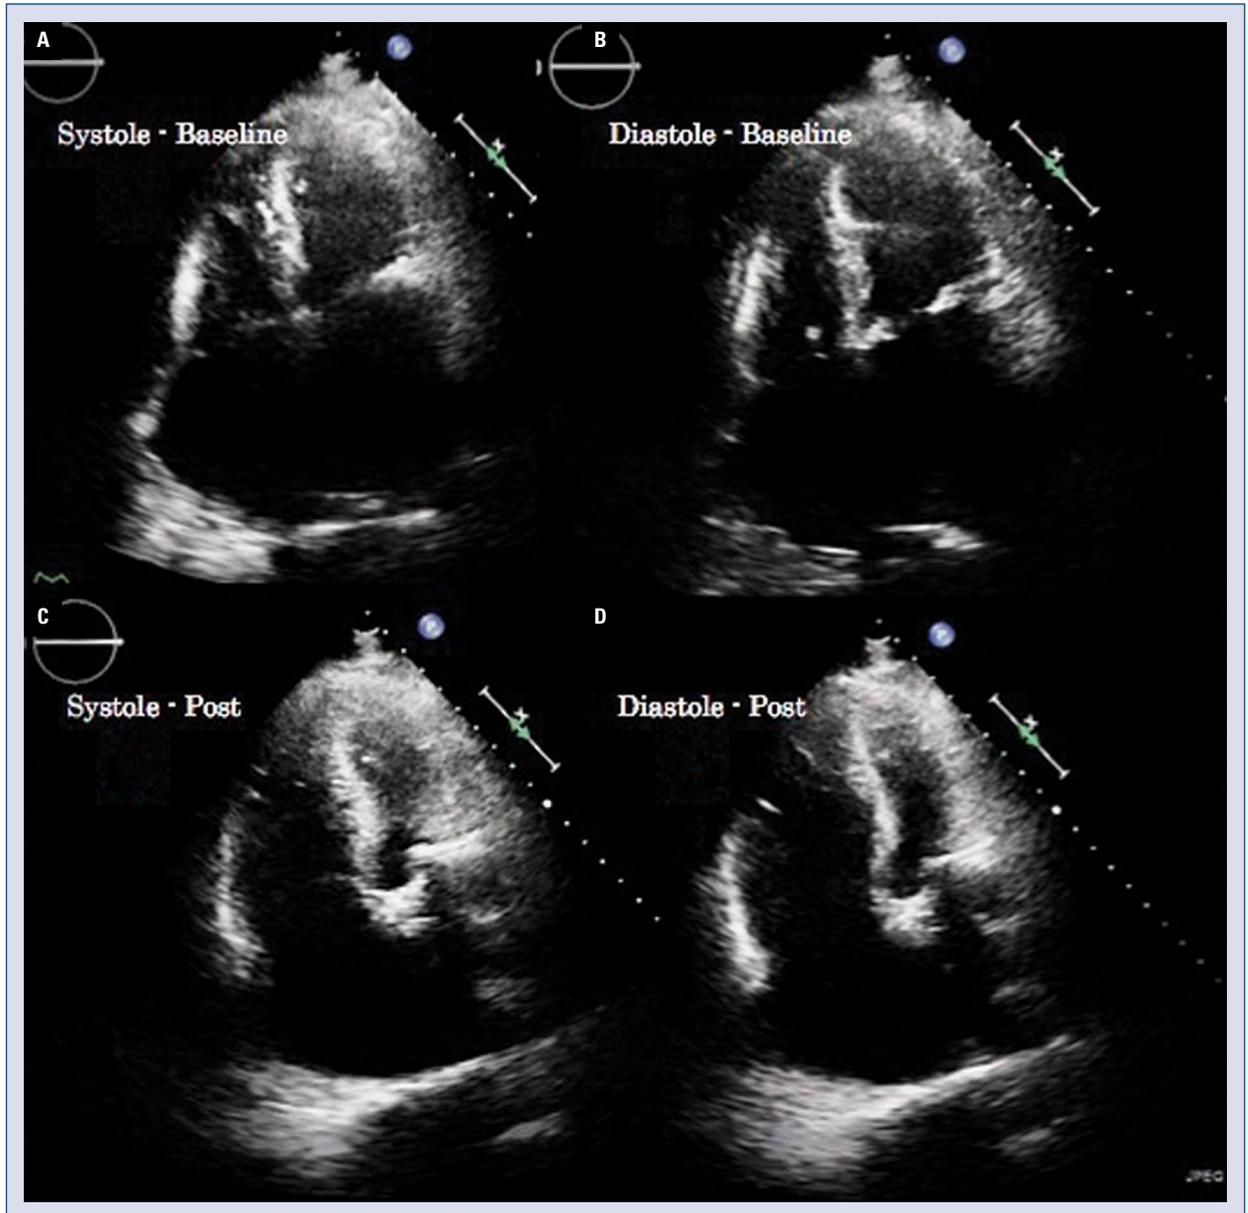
Transthoracic echocardiogram images at baseline (A, B) and after protamine administration (C, D). Image shows normal right ventricle (RV) size at baseline (A, B) and RV dilation after protamine administration (C, D).
